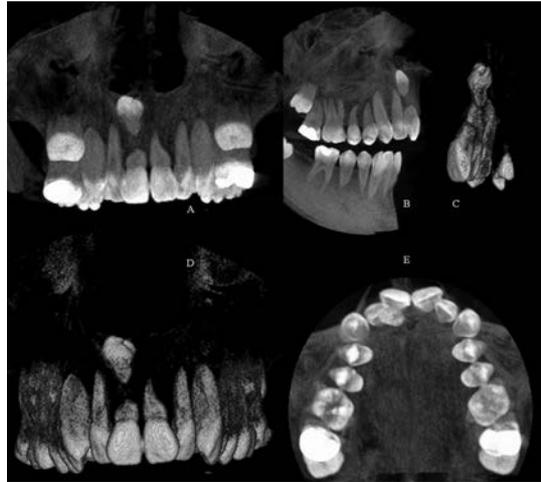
Sagittal views using CBCT technology of a patient presenting with supranumerary teeth in upper central area. The image clearly shows lack of contact and damage from part of the supranumerary teeth. The image also shows that access through the palate would probably be an efficient approach without the need for removal of the deciduous teeth.
